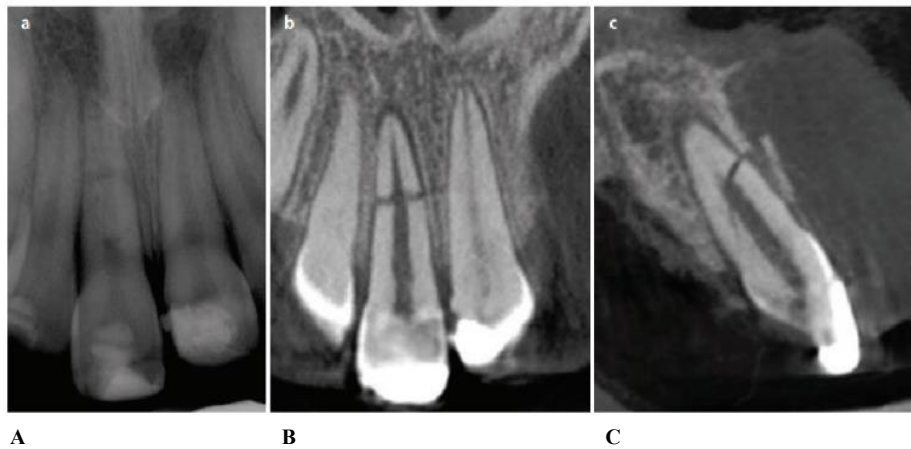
(A) Periapical radiographic view of maxillary permanent right central incisor presenting a horizontal middle third root fracture. (B) The cone beam coronal view shows the same. (C) However, the cone beam sagittal view reveals that the fracture line is oblique and more complex: from the labial, it starts horizontally but then takes a vertical direction downward to the alveolar bone crest palatally. (Nikolaos, *et al.*, 2022).
